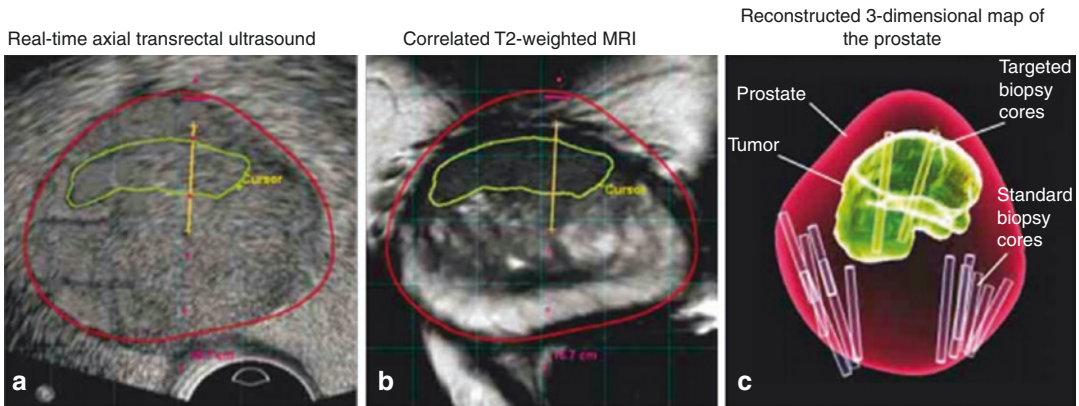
In this example, a multiparametric MRI, T2 weighted, was obtained and outlines a suspicious lesion. Axial images (not shown) were used to demarcate a lesion suspicious for prostate cancer and marked by the radiologist prior to fusion biopsy [67]. (a) Next, a real-time axial ultrasound is obtained in real-time at the time of biopsy.
